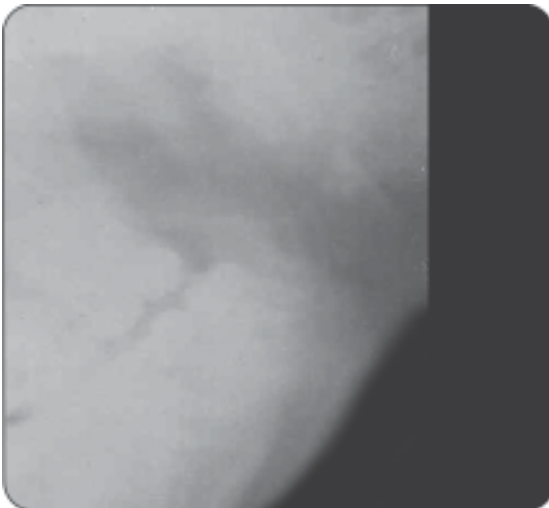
X-ray reveals periapical radiolucency in mandibular molar region
